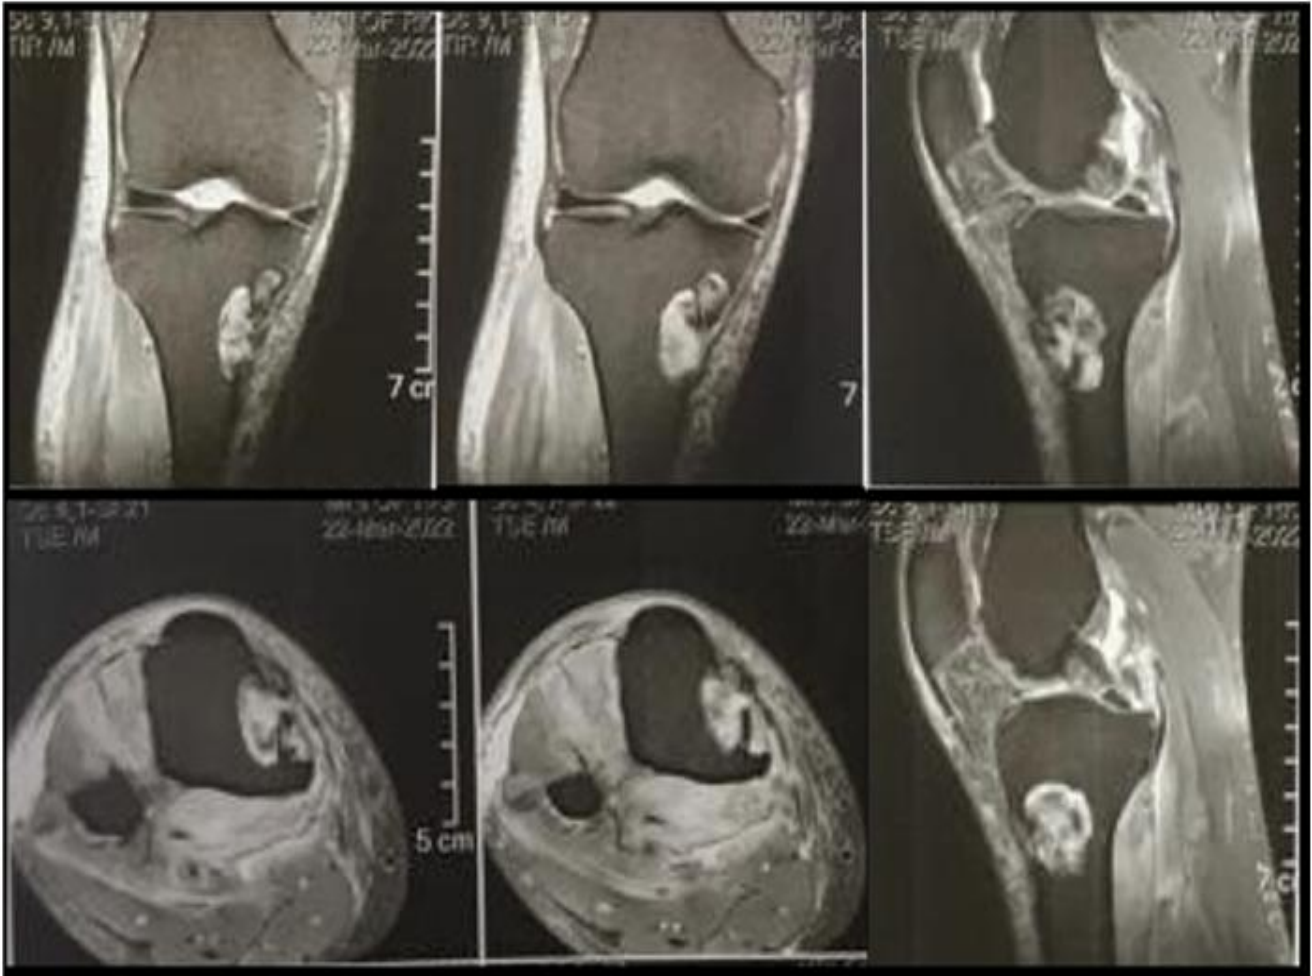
Contrast-enhanced MRI demonstrating heterogeneous enhancement of the lesion, confirming its neoplastic nature and extent within the bone.
